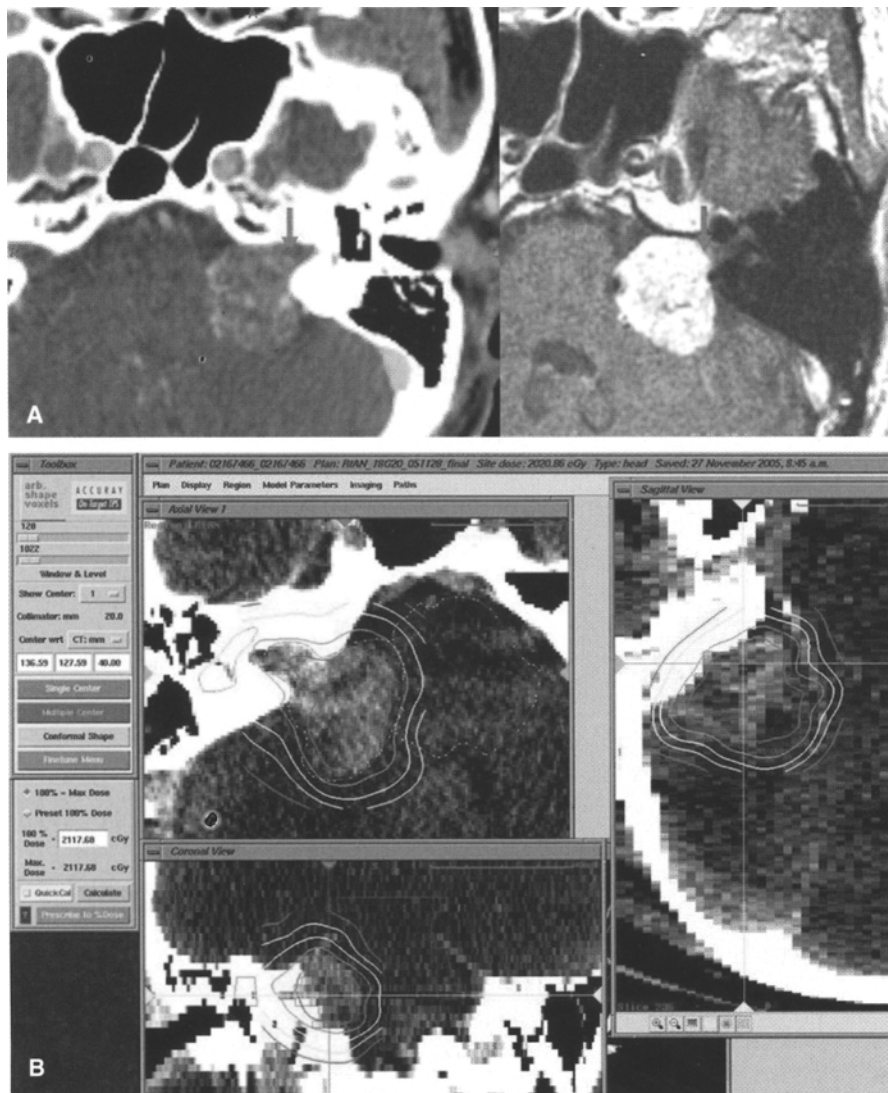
(A) Comparison of contrast-enhanced axial CT scans (*left*) with enhanced T1W MRI (*right*) of same patient harboring acoustic neuroma with intra-canalicular extension. MRI was superior in identification of tumor margin in IAC (*arrow*), facilitating protection of vital organs, such as cochlear, in IAC from irradiation. (B) Non-isocentric inverse planning: no hot or cold spot could be identified; isodose line runs along adjacent border between tumor and brain stem ideally for irradiation delivery
